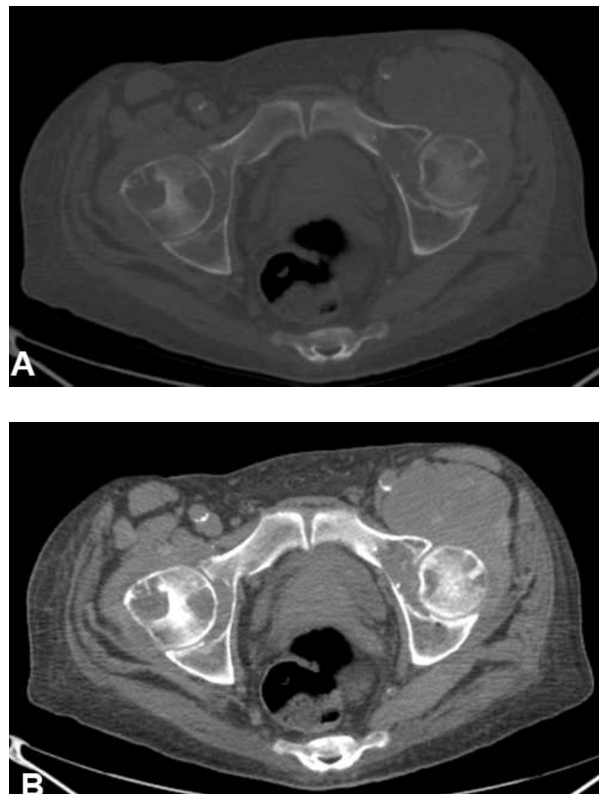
Noncontrast CT obtained in conjunction with PET/CT imaging at the level of the hips, Fig 4a filmed on bone window and Fig 4b filmed on soft tissue window. Bilateral osseous erosions involve both femoral heads and the left acetabulum.
